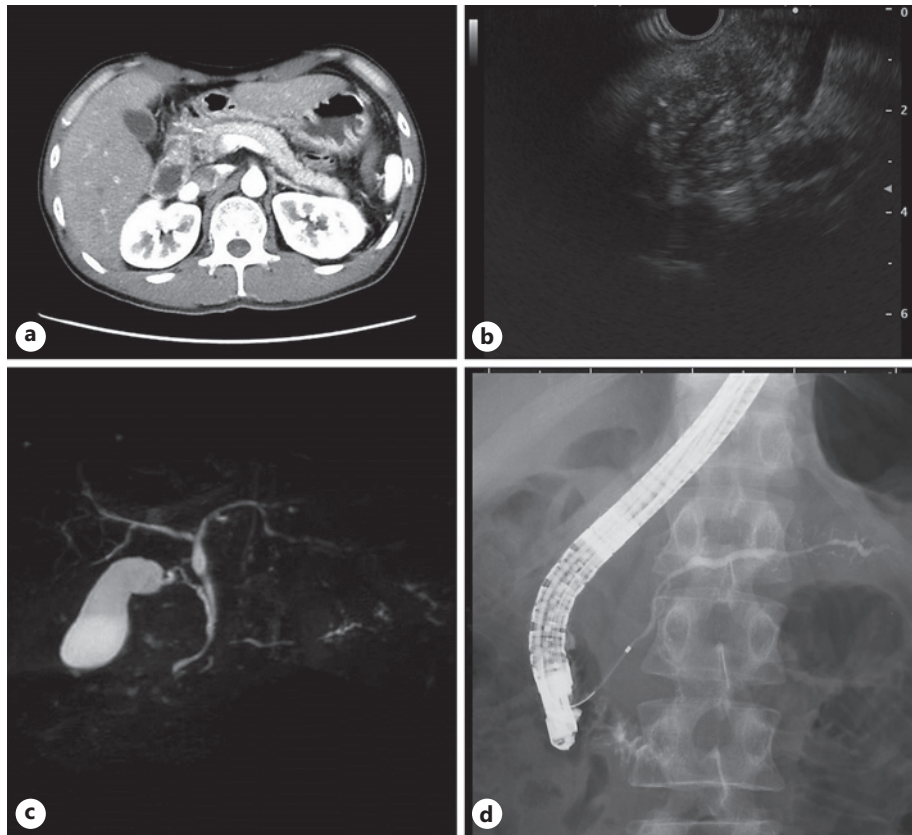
Imaging findings at initial examination. a Contrast CT shows no apparent pancreatic abnormality. b Endoscopic ultrasound shows both hyperechoic foci with posterior acoustic shadow and a honey-comb pattern of lobularity, which are considered EUS findings of chronic pancreatitis by the Rosemont classification. c Magnetic resonance cholangiopancreatography shows narrowing of the pancreatic duct in two locations. d Endoscopic retrograde cholangiopancreatography also shows irregular dilation of the main pancreatic duct and branch pancreatic ducts.
